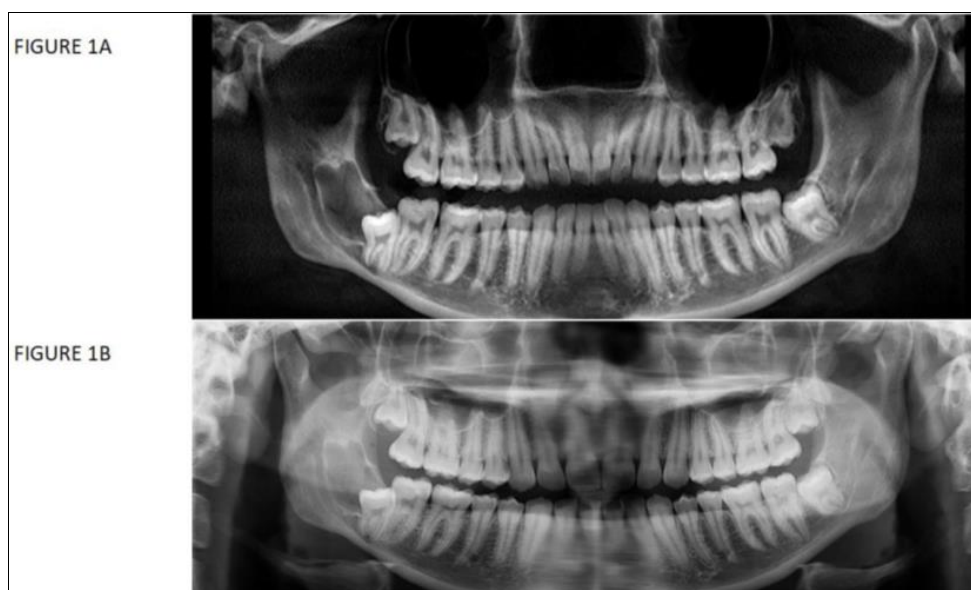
Cone Beam Computed Tomography (CBCT) and panoramic images used in Question No.3
